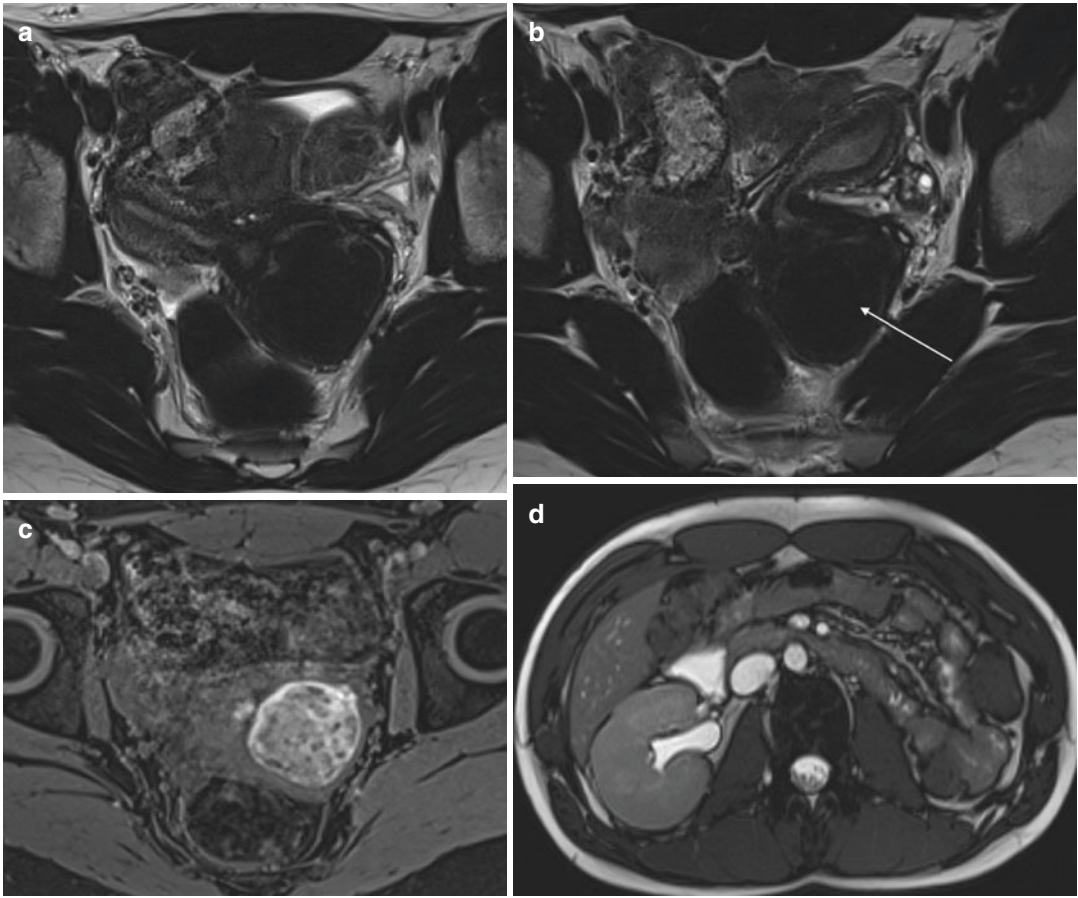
Hematocolpos in a 14 year-old girl in context of primary dysmenorrhea. (a) MR imaging: Axial T2-Weighted sequence. Right hemi-cavity of a didelphic uterus. (b) MR imaging: Axial T2-Weighted sequence. Left hemi-cavity of a didelphic uterus with blood retention
